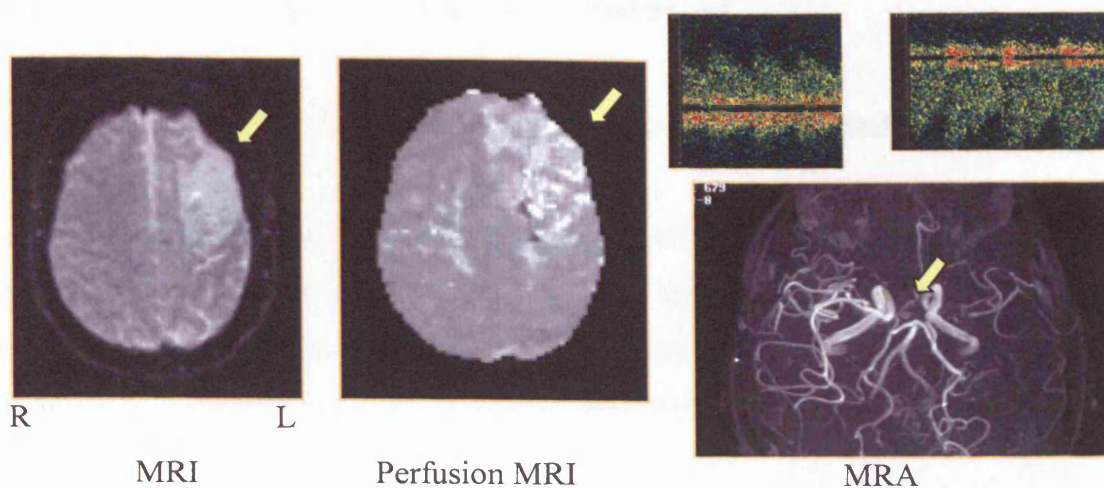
Short-term blood transfusion. *Pre-Blood transfusion.* 15-year old female, SCD (HbSS), stroke at 12 years of age. Recurrent headaches. T2-w MRI. Mature left middle cerebral artery (MCA) infarct, left caudate nucleus infarct and atrophy. Perfusion MRI: Abnormal perfusion MRI. Increased mean transit time of the passage of IV contrast bolus in the left MCA territory, including the left frontal region. MRA. Stenosis of the left MCA and Left A1 (anterior cerebral artery), collateral vessels. TCD: decreased left MCA blood flow velocities and turbulent left ACA flow. R: right; L: left.
